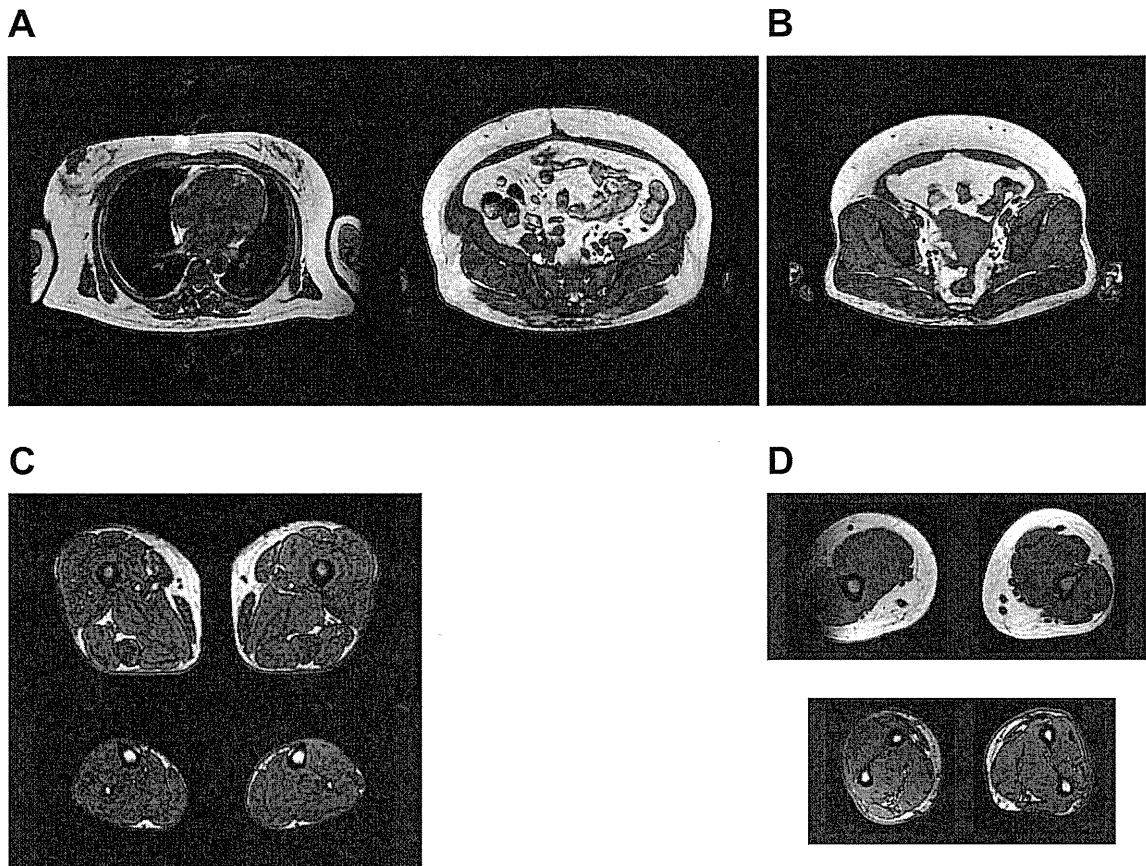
The figure shows magnetic resonance imaging (MRI) results for Patient 1. A. Thoracic MRI images taken at the level of the fourth thoracic vertebrae (left panel) and abdominal MRI images taken at the umbilical level (right panel) showed the preservation of subcutaneous fat in the thoracic and abdominal regions. B. A T1-weighted MRI image taken at the level of the gluteal fat indicated a striking loss of gluteal subcutaneous fat. C. MRI images taken at the level of the thigh (upper panel) and calf (lower panel) revealed a nearly complete absence of subcutaneous fat. Patient 1 had decreased amounts of subcutaneous fat, particularly in the antero-lateral and posterior thigh and calf regions. D. MRI images taken at the level of the arms (upper panel) and forearms (lower panel) revealed a marked loss of subcutaneous fat in the forearms and preservation of fat in the arms.
